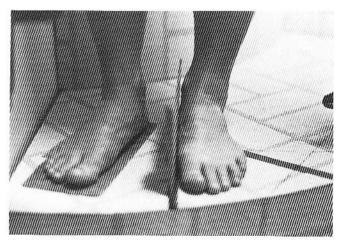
This shows the technique for the left foot lateral x-ray angle and base of gait.
